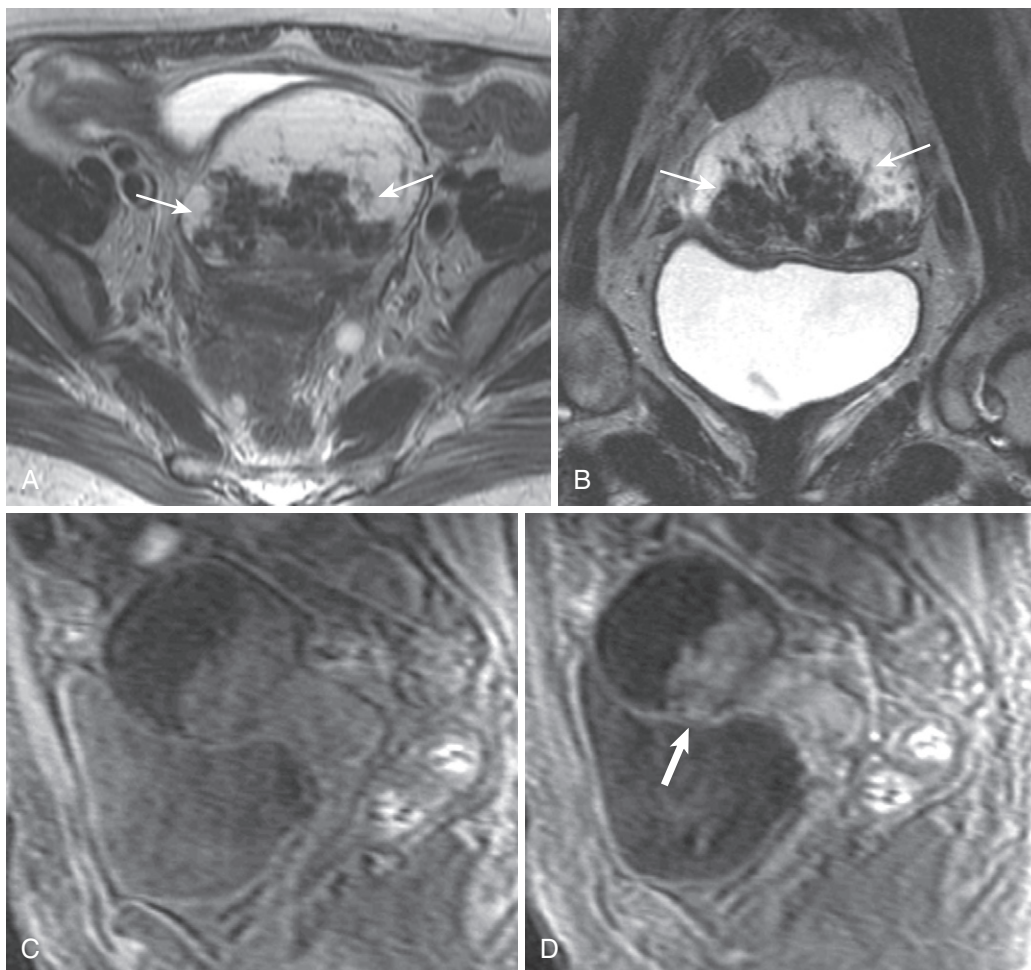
Malignant features of ovarian epithelial neoplasm. Axial (A) and coronal (B) T2-weighted images show gross mural papillary excrescences (*arrows*) virtually filling the contents of the mildly thick-walled unilocular cystic adnexal mass. Precontrast (C) and post-contrast (D) fat-suppressed T1-weighted sagittal images show enhancement of the mural excrescences (*thick arrow* in D) signifying solid, viable tissue in a serous cystadenocarcinoma. A low-grade seromucinous adenocarcinoma in a different patient (axial T2-weighted [E], axial T1-weighted [F], sagittal T2-weighted fat-suppressed [G], and sagittal T2-weighted enhanced [H] images) manifests similar—albeit less complex—features with a smaller, more confined papillary excrescence (*thin arrow* in E-G) exhibiting mild enhancement (*thick arrow* in H).
